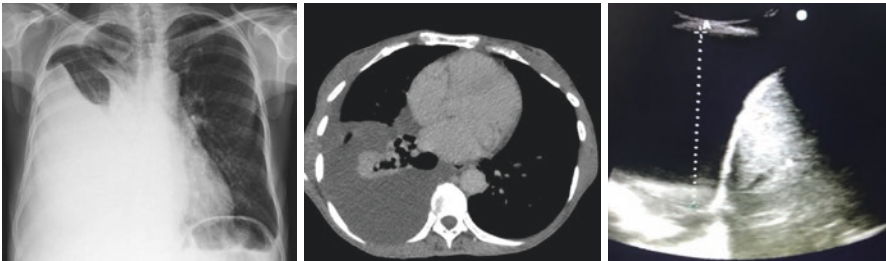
CXR and cross sectional CT showing large right pleural effusion; US image showing large right anechoic effusion
